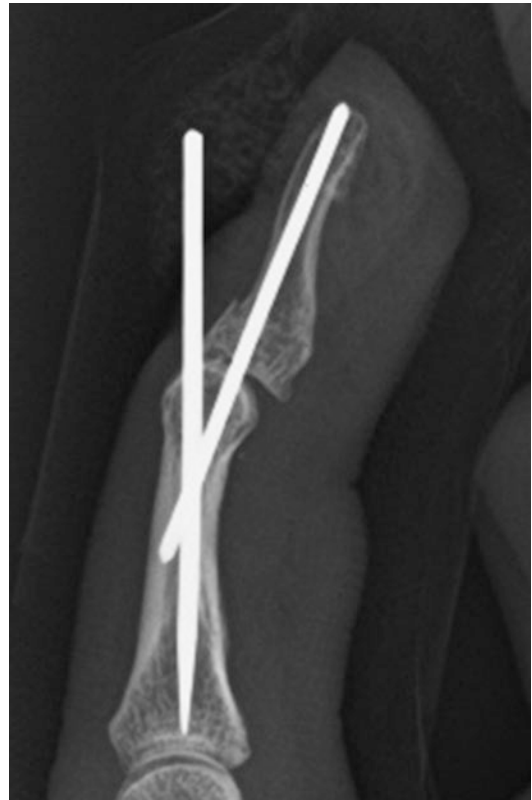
X-ray lateral view of bony mallet finger with two Kirschner wires
